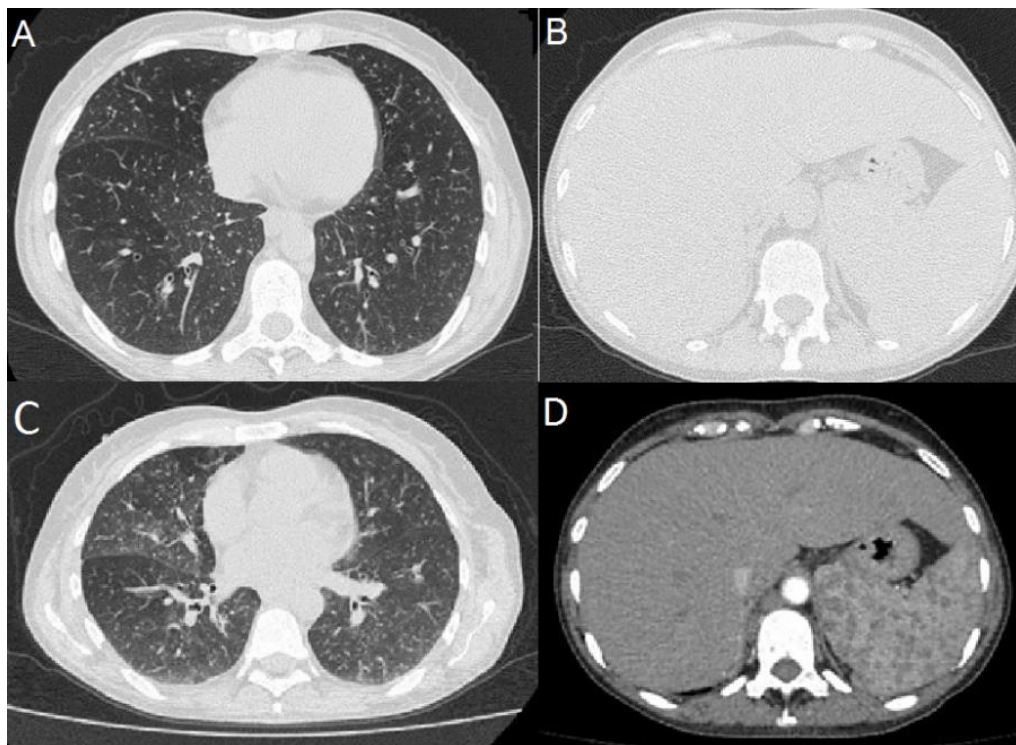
Computed tomography of the chest (A) and abdomen (B) of July 17, 2020. (C) and (D) images show follow up computed tomography performed on September 14, 2020
